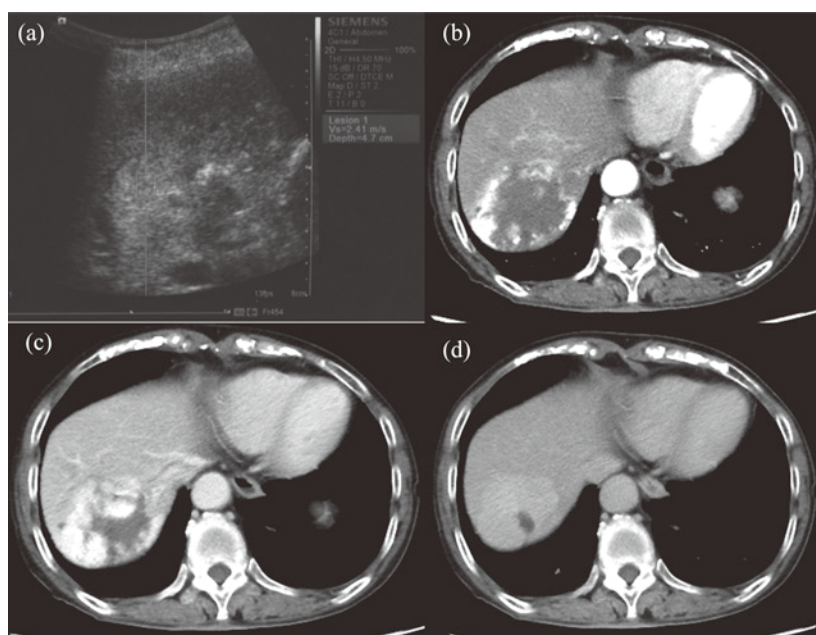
The measurement of the acoustic radiation force impulse value within the region of interest of cavernous hemangiomas. The SWV was measured when the region of interest box was placed within the cavernous hemangioma. (a) The measurement of the SWV, (b) CT scans in the arterial phase, (c) CT scans in the portal phase, (d) CT scans in the post-vascular phase.
